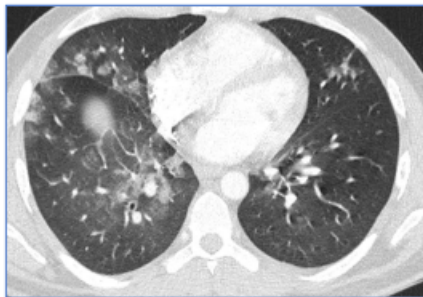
CT chest with infection
